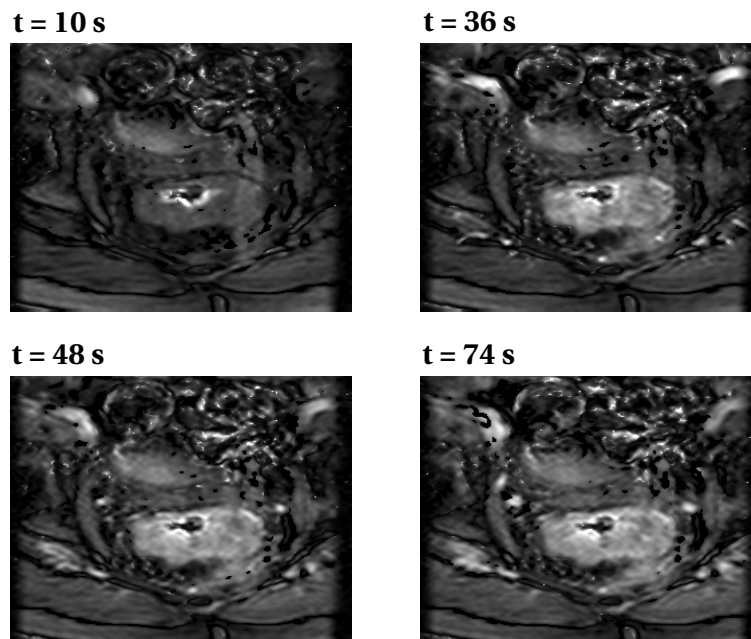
DCE-MR images of one of the patients in the Oxytarget study, showing the distribution of contrast agent after 10 s, 36 s, 48 s, and 74 s. The axes indicate the pixel locations. There is little contrast in the first image, which is before any contrast agent has entered the blood stream. In the second image, the signal in the tumour (in the centre of the image) and the two arteries in the upper corners is enhanced. In the last image the signal enhancement in the arteries has decreased, but the signal enhancement in the tumour is still present.
